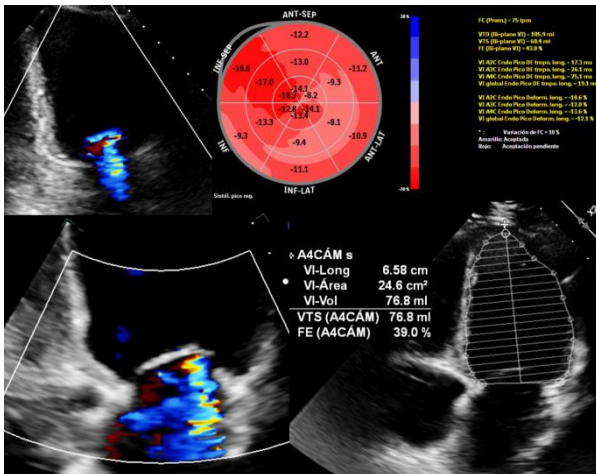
Transthoracic echocardiography reveals systolic dysfunction with an ejection fraction (EF) of 39%, a global longitudinal strain (GLS) of 12.1%, and mild mitral regurgitation.
